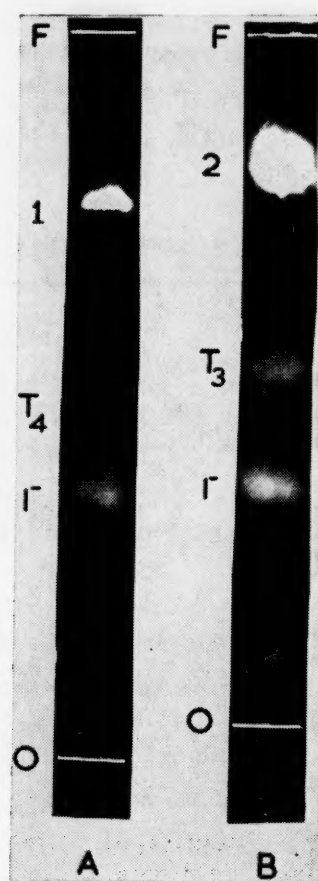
Radiochemical change brought about as a result of irradiation of ^{131}I -labelled (A) L-thyroxine and (B) 3,5,3'-triiodo-L-thyronine of low specific activity with X-rays from the 4 MeV Linear Accelerator. Specific radioactivity: 0.002 mC/ μ mole of thyroxine; 0.0016 mC/ μ mole of triiodothyronine. ^{131}I distribution before
